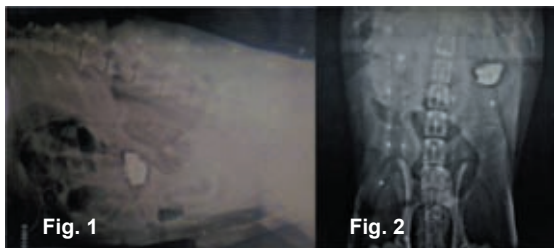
Lateral and ventrodorsal abdominal radiographs
